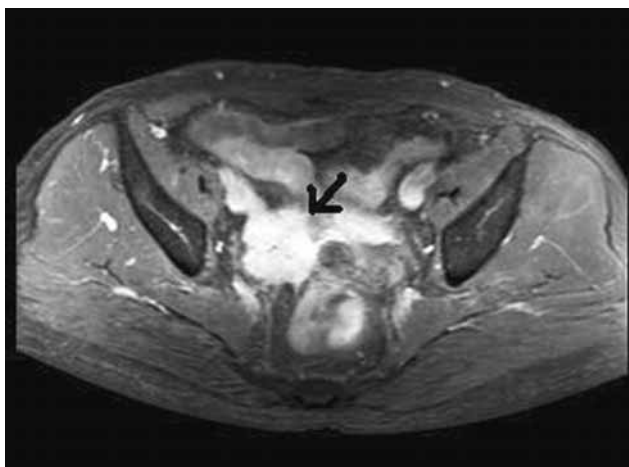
CT indicating a solid mass of the right pelvis.
